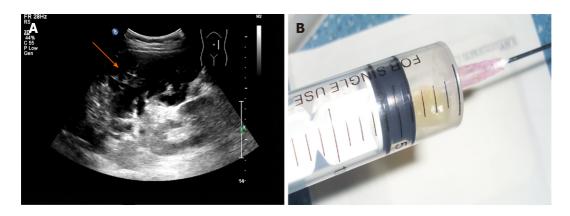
Ultrasound image and transabdominal ultrasound-guided percutaneous aspiration of the mass in the left upper abdomen. A: A large mass with flocculent and stripe-like echoes (arrow) was detected in the left middle and upper abdomen by ultrasound; B: Yellow gelatinous material was aspirated from the abdomen via transabdominal ultrasound-guided percutaneous aspiration.
